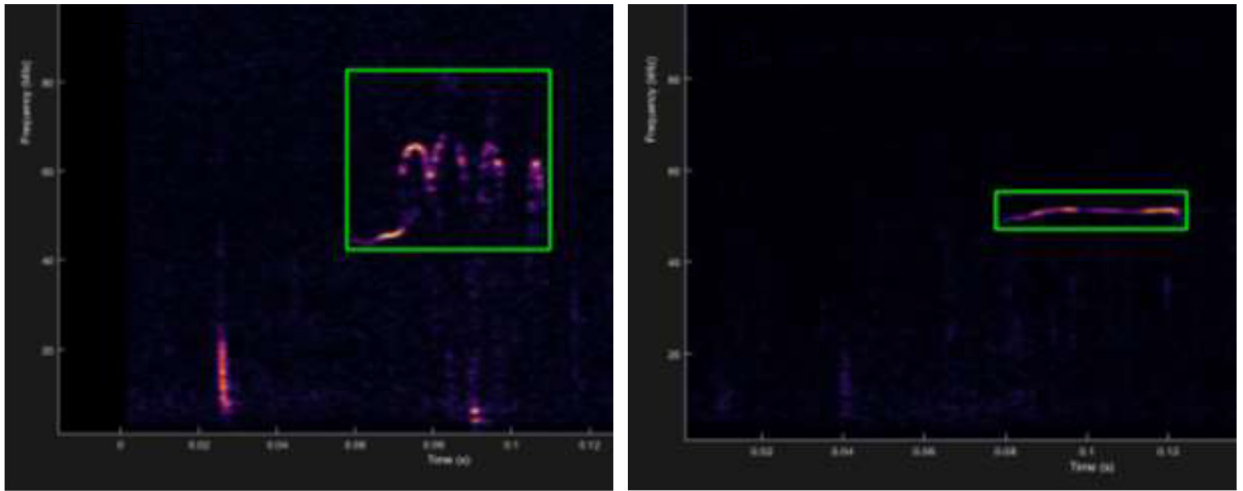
Ultrasonic Vocalization Spectrograms
